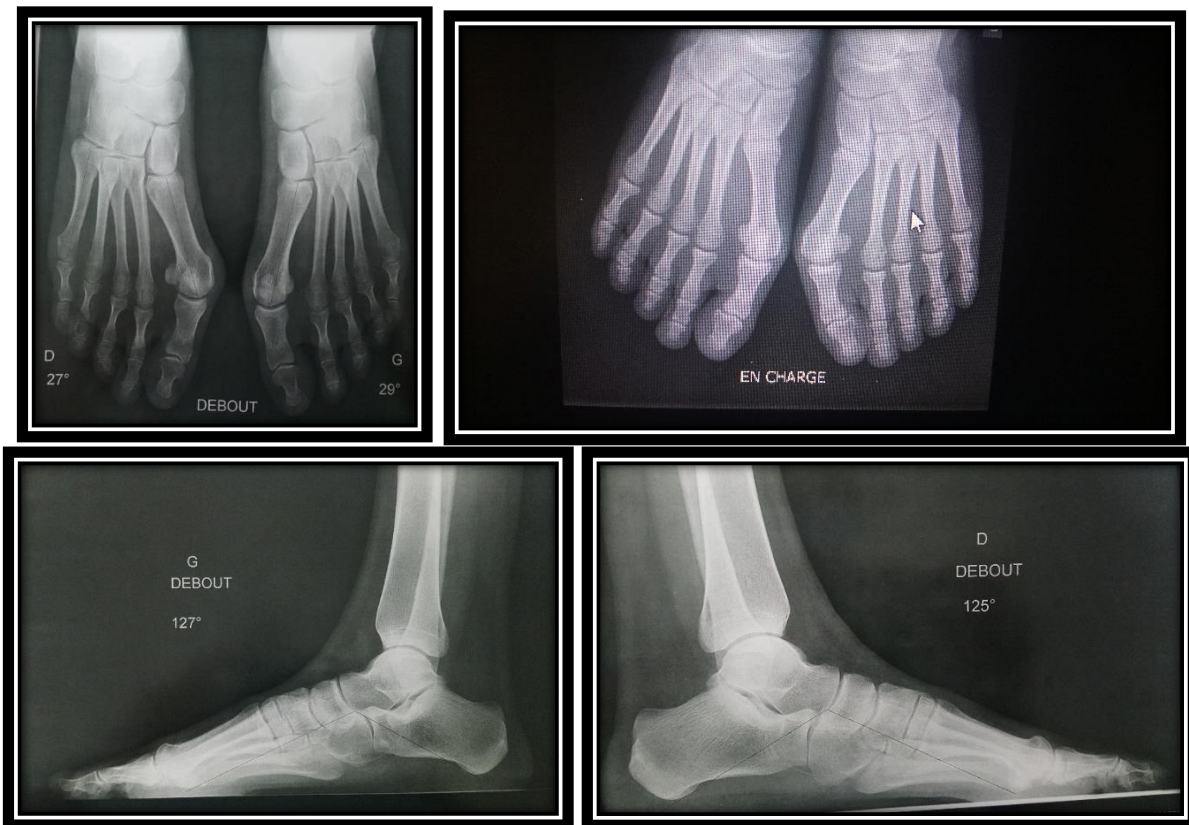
X-ray view of foot (face/ profile: in charge with standing position)
